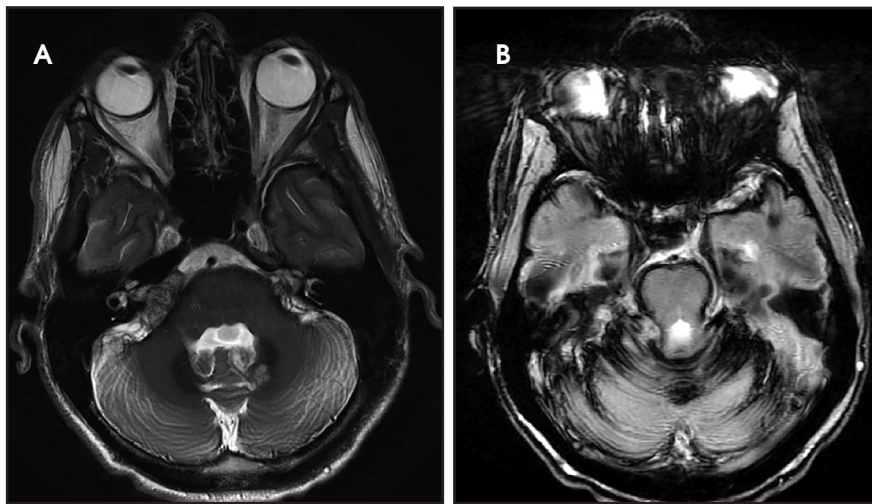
(A) Thick hypointensity lining the surface of the pons and cerebellum on T2-weighted and (B) GRE images in a patient with superficial siderosis.
